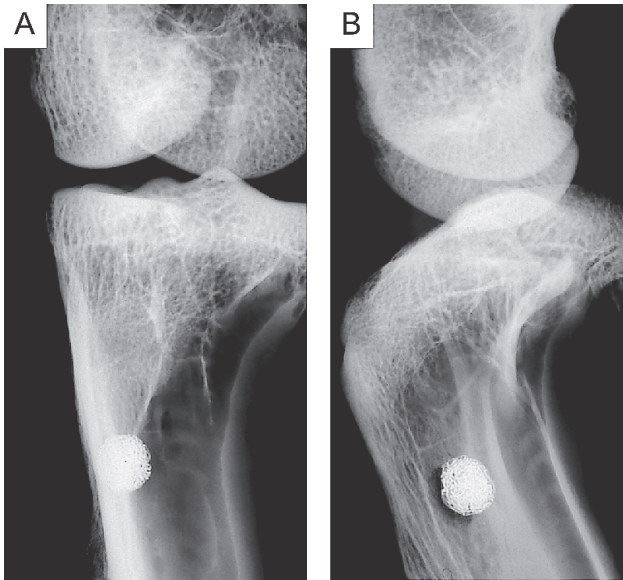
Postoperative soft X-ray radiographs showing a titanium wire ball implanted into the medial condyles of the right tibia. A, Anteroposterior; B, lateral.
